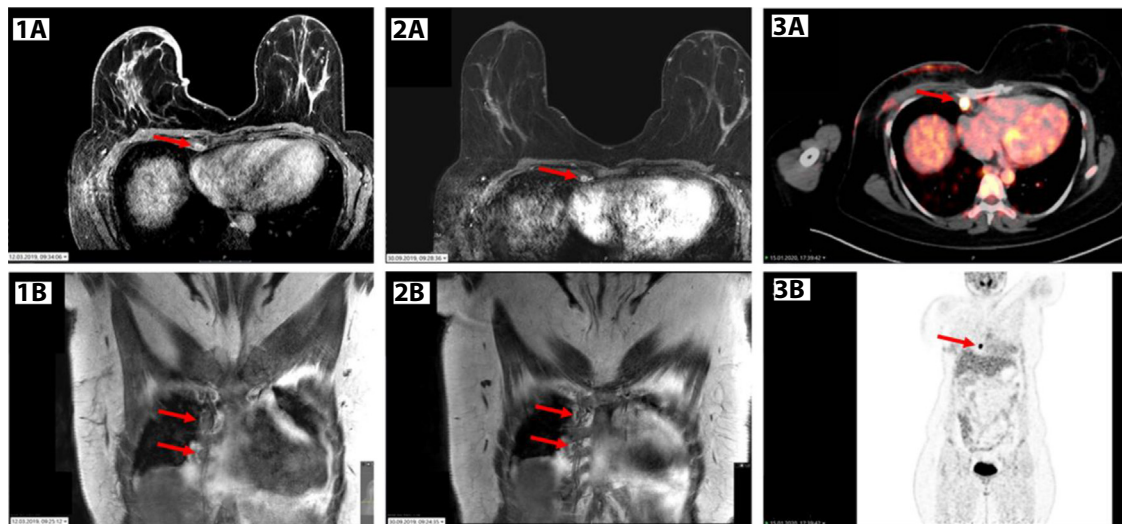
IMN dynamics before/after NACT under consideration of follow-up imaging: 1-right-sided breast cancer patient with visible IMN in the second and third intercostal spaces in axial (A) and coronal (B) planes of pretreatment MRI. 2-same patient after 6 months of NACT with clinical complete response of primary tumor and axillary metastasis and response of the visible IMN in axial (A) and coronal (B) planes. 3-recurrence of initially visible IMN with response after NACT, subsequently increasing 6 months later in axial (A) and coronal (B) planes of PET/CT. Red arrows indicate the internal mammary lymph nodes. *Abbreviations:* IMN = internal mammary lymph node(s); MRI = magnetic resonance imaging; NACT = neoadjuvant chemotherapy; PET/CT = positron emission tomography/computed tomography. A color version of this figure is available at [10.1016/j.ijrobp.2026.07.050].
